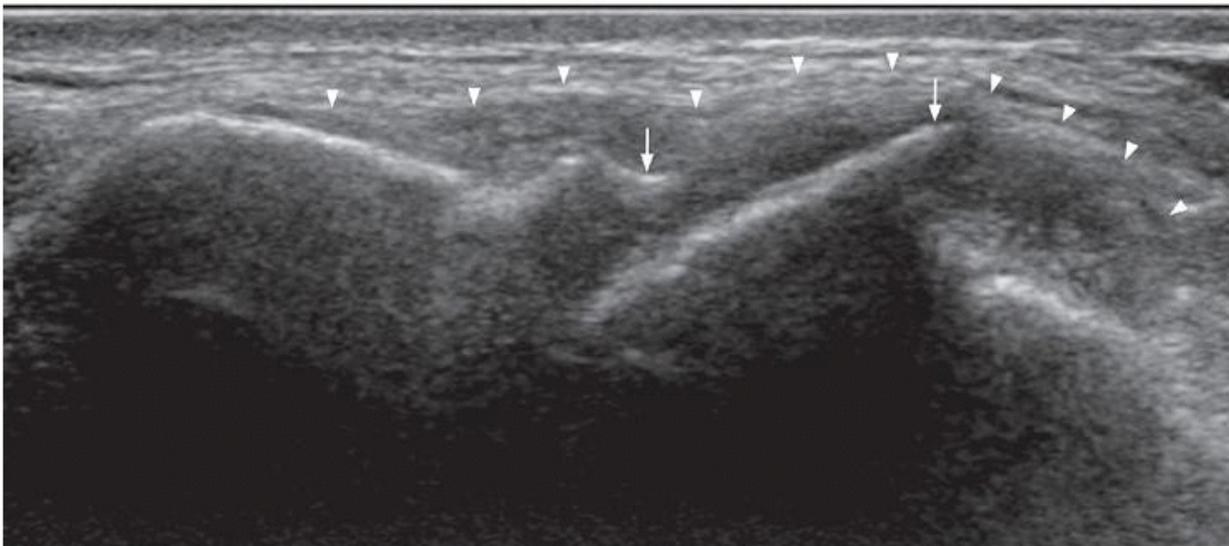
Longitudinal ultrasound anterolateral aspect of ankle showing quite severe osteoarthritis with joint space narrowing, marginal osteophytosis (arrows), together with moderate capsular thickening (arrowheads). Ultrasound-guided joint aspiration or synovial biopsy may be helpful. Ultrasound ensures accurate needle placement, avoids nerves and vessels, and helps to minimize the risk of cross contamination, for example, between joints and tendon sheaths.^{45, 67, 68, 69, 70, 71, 72, 73, 74, 75, 76, 77, 78, 79} A longitudinal anterior approach with the foot plantar flexed provides the best visualization of anterior tibiotalar joint. Remember that the deep peroneal nerve lies just lateral to the dorsalis pedis artery.
